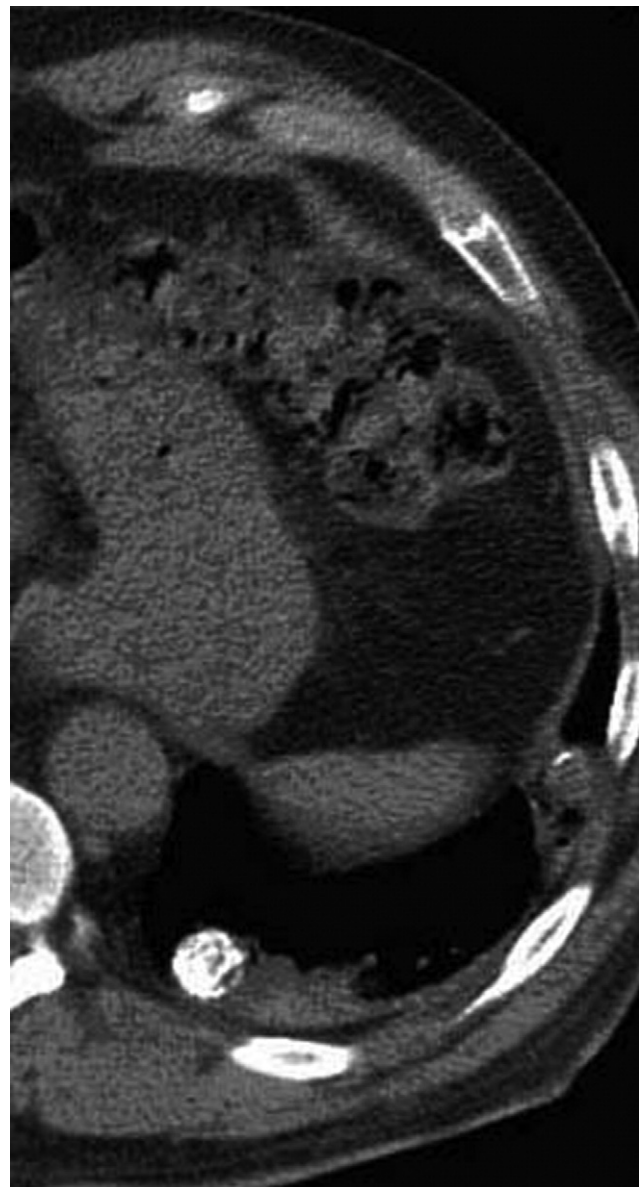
Noncontrast chest CT scan shows wedged-shaped abnormality consistent with pulmonary infarction of the left lung after chemoembolization.
